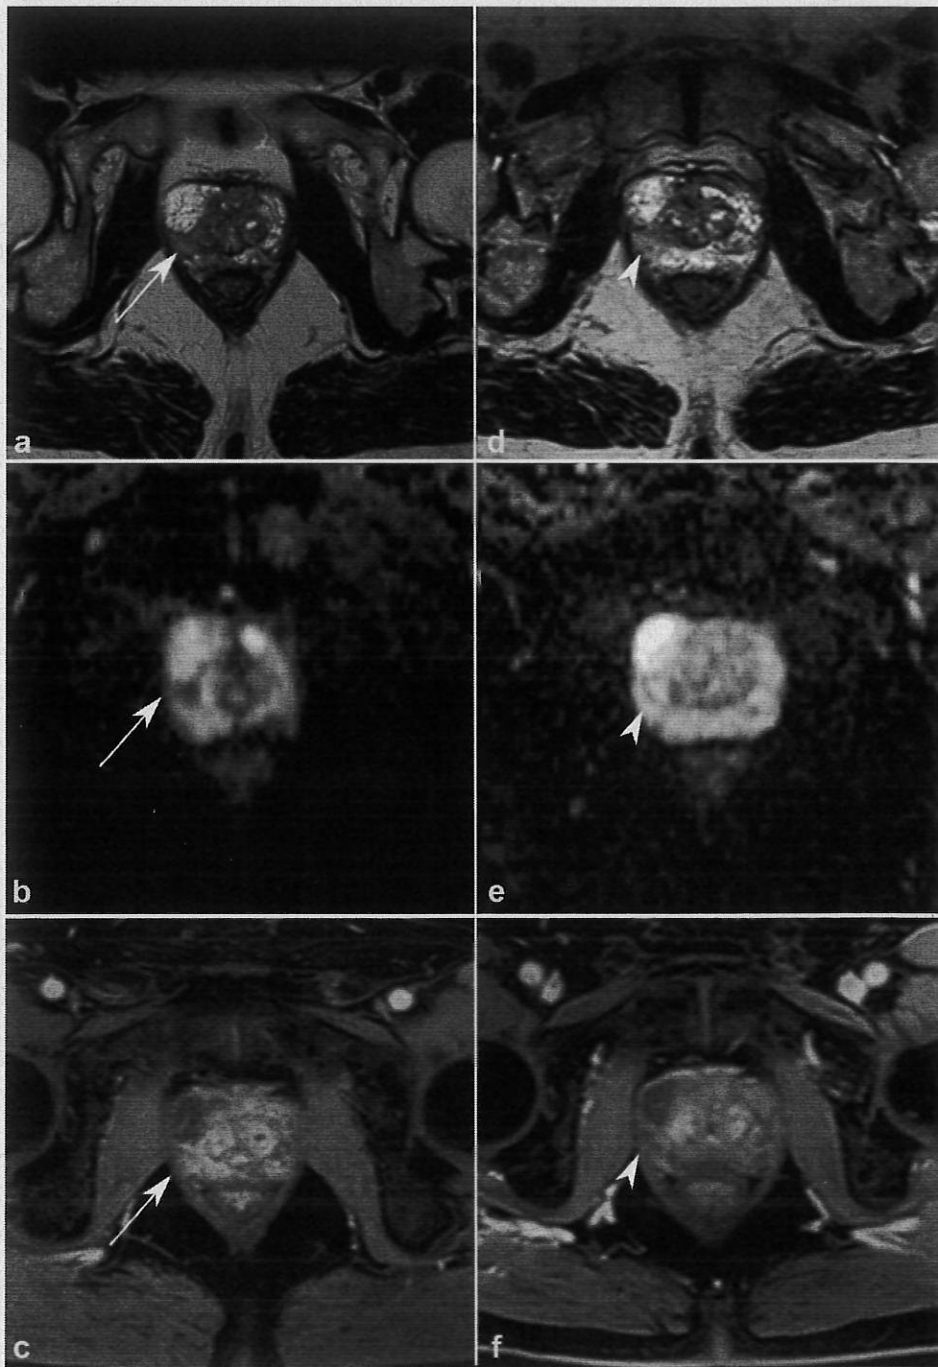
Efficacy of the procedure: At baseline, patient 2's multiparametric MR imaging showed a Prostate Imaging Reporting and Data System v2.4 target lesion of 9 mm in the right apex (white arrow) with a circumscribed homogenous T2 hypointense (a), markedly hypointense on ADC map (b), with a positive focal enhancement in dynamic contrast-enhanced imaging (c). At 6 months following PAE, the circumscribed hypointense was no longer visible in 3D T2-weighted multiparametric MR imaging (white arrow head, d), ADC map (e), and no focal enhancement was visible in dynamic contrast-enhanced imaging (f).
